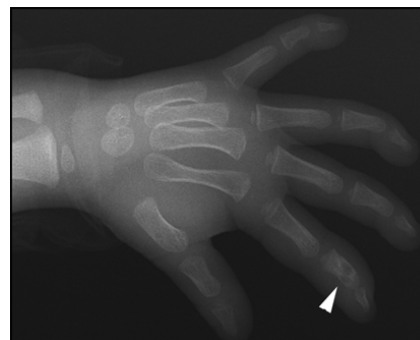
A 3 years old boy with phalangeal TB. Palm radiograph shows cystic low-density shadow in the bone marrow cavity of the middle phalanx of the index finger (arrow).
